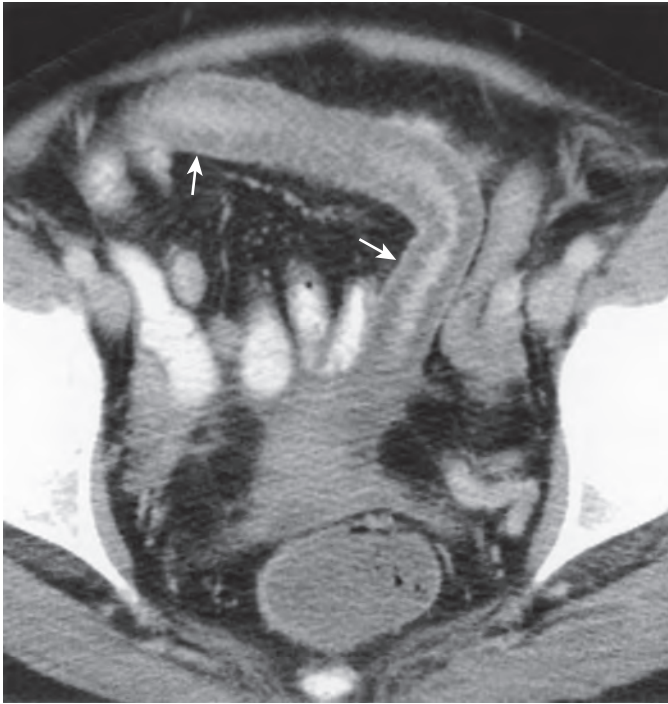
Neutropenic enteritis. CT through the pelvis shows marked thickening of an ileal loop (arrows) with a mural stratification pattern because of low-attenuation submucosal edema and inflammation. Other images revealed marked cecal inflammation compatible with typhlitis.
